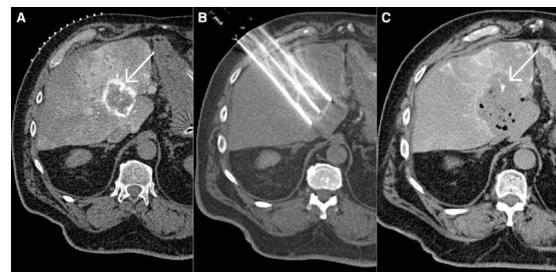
CT-guided irreversible electroporation (IRE) for HCC. (A) Arterial-phase CT shows a hyperenhancing hepatic tumor. (B) Multiple IRE electrodes are placed in parallel under CT guidance. (C) Post-IRE CT demonstrates a hypoattenuating ablation zone with intralesional gas while adjacent vessels remain patent, confirming successful non-thermal tumor ablation.
